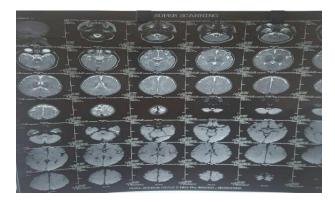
MRI brain scan 2.
